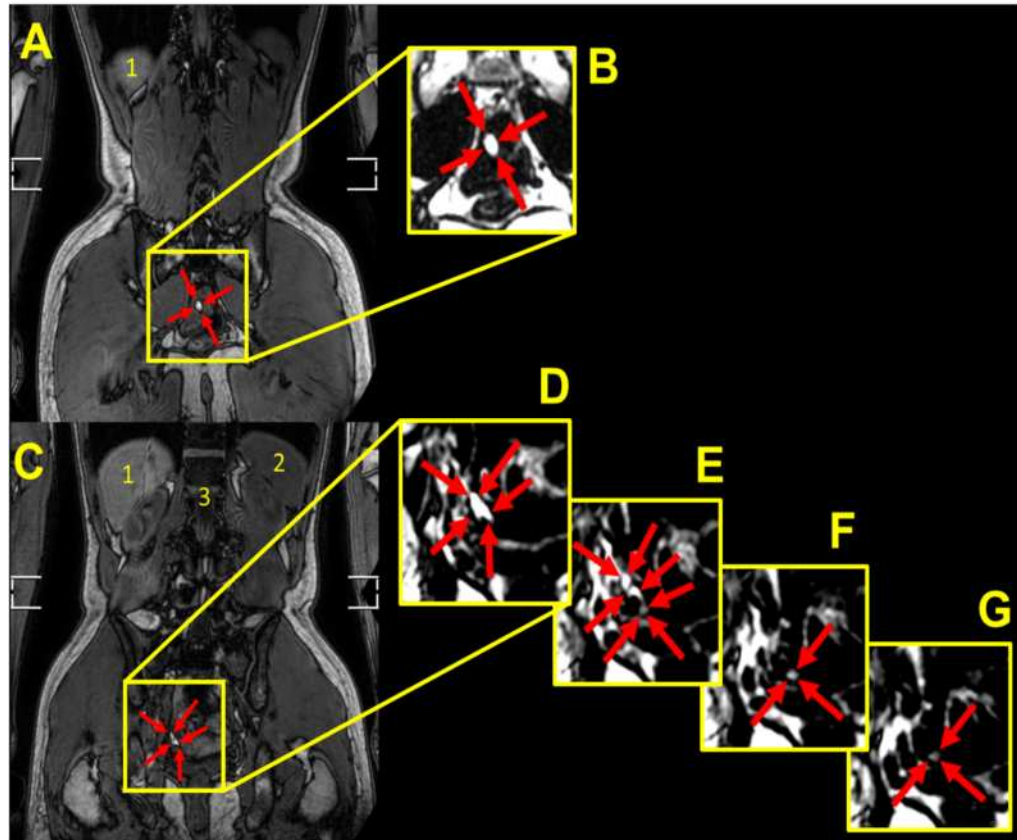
(A) Coronal, fat and water out of phase MRI image of the abdomen of a representative participant (participant number 8), 90 minutes after consumption of a 36 mg weight gain coated capsule. The filled capsule, indicated by the red arrows inside the yellow box, appeared bright and intact in the terminal ileum. Inset (B) shows an enlarged fat-only coronal MRI image of the capsule. (C) At time 135 minutes the capsule was detected more distally in the terminal ileum. By this time the capsule appeared to have lost integrity, deformed and unevenly filled. The inset (D) shows an enlarged fat-only MRI image, confirming loss of integrity. Insets E, F and G show contiguous fat-only coronal MRI image planes respectively going more posteriorly from inset D. They capture the deformed end of the capsule (E) and oil leaked out of the capsule into the terminal ileum (F and G) indicated by the red arrows. Anatomical landmarks are indicated in A and C by numbered labels as liver (1), spleen (2) and spine (3).
